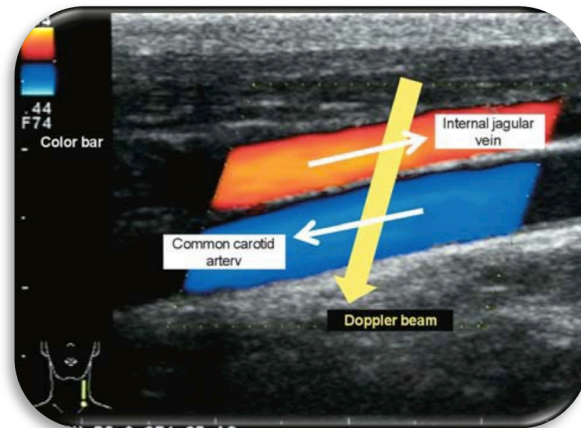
Colour Doppler Method.
